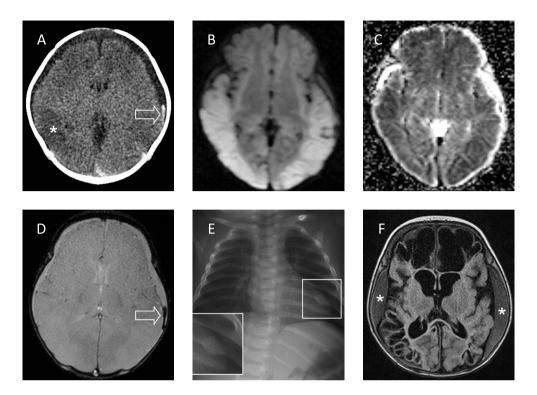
A two-year-old girl with a subdural hematoma along the left convexity (arrow) and diffuse ischemia (asterisk), as a result of abusive head trauma. Figure 6b. Diffusion-weighted MRI, obtained on the same day as the MRI, shows extensive temporo-parietal cytotoxic edema as a result of disturbed perfusion (restricted diffusion). Figure 6c. Diffusion-weighted MRI (apparent diffusion coefficient) shows a corresponding decrease in signal intensity. Figure 6d. Blood clot in the subdural hematoma shown on the FLuid Attenuation Inversion Recovery (FLAIR) image. This sequence uses a long T1 in order to suppress the effect of fluid on the images. It can be used to show lesions that are normally obscured by the high signal intensity of fluid. Figure 6e. Chest radiograph obtained three weeks after the incident shows a consolidating posterior rib fracture (see insert). This was not visible on the initial skeletal survey and this shows the importance of a repeat skeletal survey in case of inconclusive findings. Figure 6f. MRI obtained after two months of the incident shows extensive diffuse multicystic encephalomalacia and bilateral subdural hypermas (asterisk).
